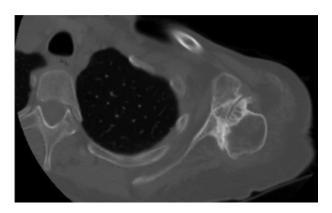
Computed tomography, axial view of the left dysplastic glenohumeral joint of patient 2.
